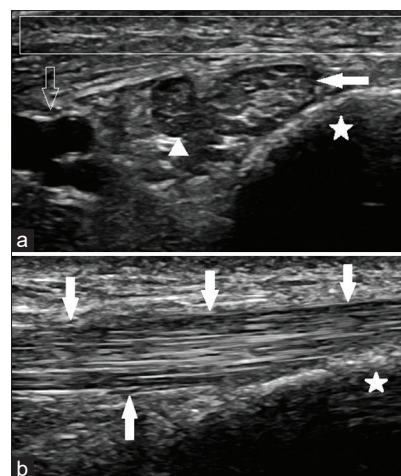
Normal sonographic appearance of the right medial ankle and posterior tibial tendon in a 34-year-old man. (a) Short-axis and (b) long-axis ultrasound images demonstrate the normal appearance of the subcutaneous fat with the absence of any edema (empty rectangle). The empty rectangle also represents the area cropped for the image review. The normal posterior tibial tendon (solid arrows) at the level of the medial malleolus (stars) is also shown with the normal homogenous, defined, hyperechoic, fibrillary pattern and no evidence of tenosynovitis. The flexor digitorum longus tendon (triangle) and posterior tibial vascular structures are also depicted (empty arrow)
